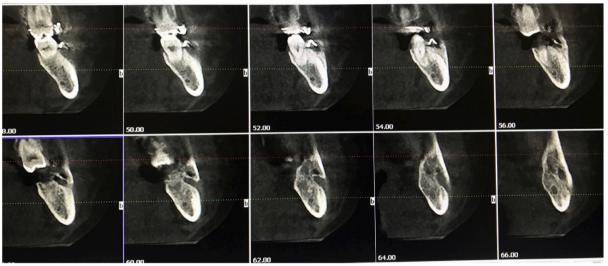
Post Surgical CBCT images IAC can be clearly distinguished with NAMAF.
